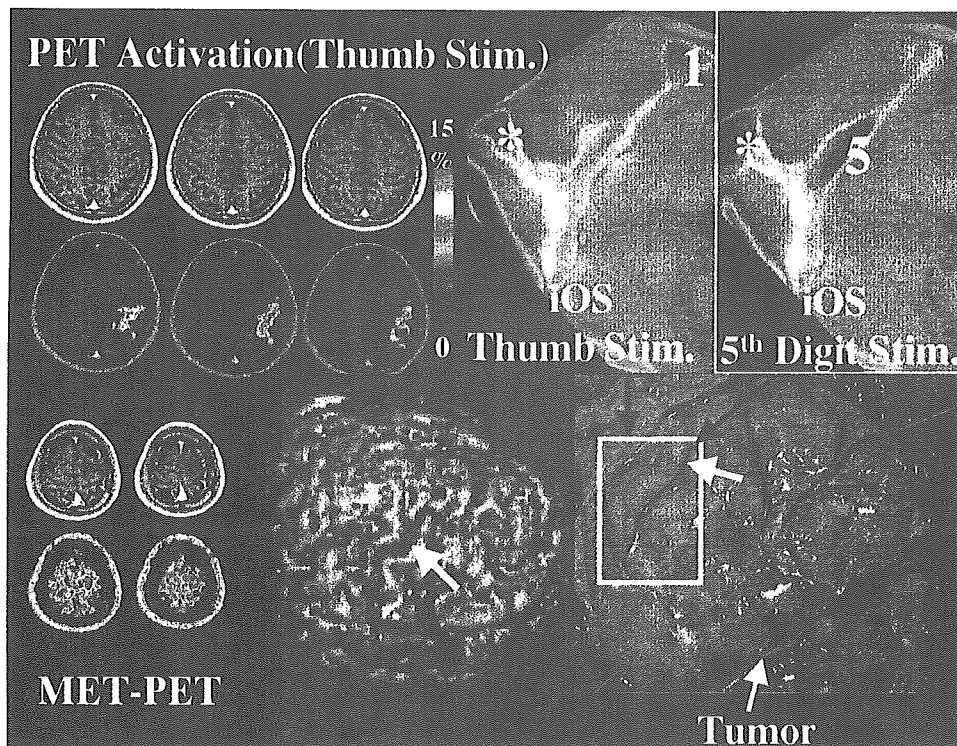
Case 10. Images obtained for a comparison of PET sensory activation, intrinsic optical signal (iOS), and intraoperative findings in a patient with an oligodendroglioma in the left premotor area. The tumor area was delineated on MET-PET scanning. *Upper Left:* Results of a PET activation study with $H_2^{15}O$ are displayed. *Upper Right:* Subtraction images indicating the increase in CBF in response to electrical stimulation of the right thumb are superimposed on the MR image (color scale and accompanying percentage represent the increase in CBF). Location of intrinsic optical signals elicited on electrical stimulation of the first and fifth digits are displayed. Different spots close to the central sulcus were activated by stimulations of the different digits (marked as 1 and 5), but the identical area close to the postcentral sulcus was also activated by two digits (marked with an asterisk). *Lower Left and Center:* The tumor area (yellow), the area with more than 10% increase in CBF on thumb stimulation (red), and the cortical vein (blue) are displayed on MET-PET scans and in the 3D brain surface image, respectively. The increase in CBF was most prominent in the deeper portion of the central sulcus, but the edge of the CBF increase extended to the brain surface. Its location is marked by a yellow arrow in the 3D image. *Lower Right:* The location of the intrinsic optical signal in response to thumb stimulation is marked by a yellow arrow in the brain surface photograph. Note that the two black arrows point out an identical bend of the postcentral gyrus.
